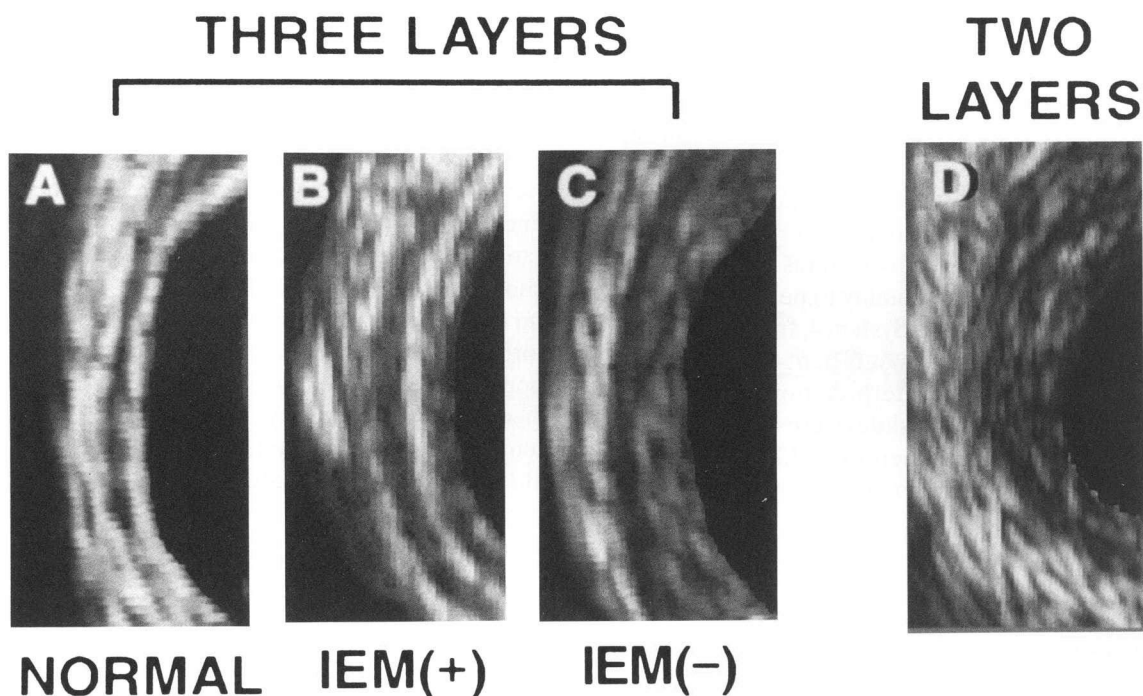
Examples of intravascular ultrasound images with a three-layered appearance (A-C) and a two-layered appearance (D) (IEM, internal elastic membrane, present (+) or absent (-)).
